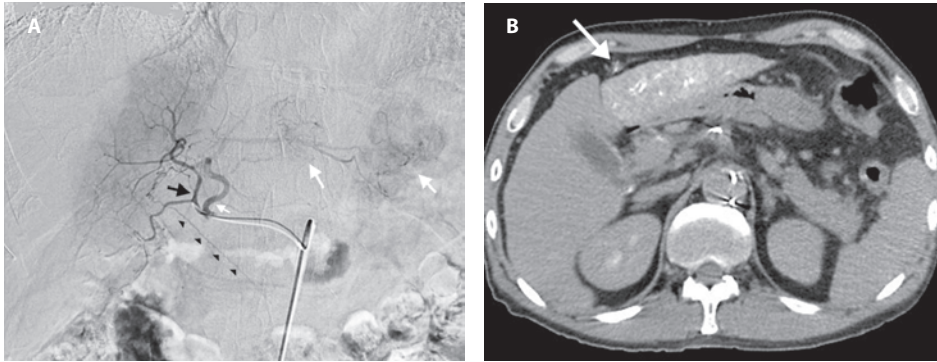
Patency of the hepatic falciform artery (HFA) in a 67-year old male with multifocal bilobar hepatocellular carcinoma (HCC) demonstrated on both digital subtraction angiography (DSA) and computed tomography hepatic arteriography (CTHA). a) Selective DSA from the middle hepatic artery (MHA). The MHA (black arrow) gives rise to the HFA (arrowheads). Reflux is seen into the left hepatic artery (small white arrow) with early tumor enhancement of tumors in segments 2 and 3 (large white arrows). b) CTHA also shows the HFA (arrow) to be patent. The patient was not considered to be at risk of non-target radiation to the HFA vascular territory as Y90 microspheres were infused super-selectively into the left and right hepatic artery and not the MHA.
